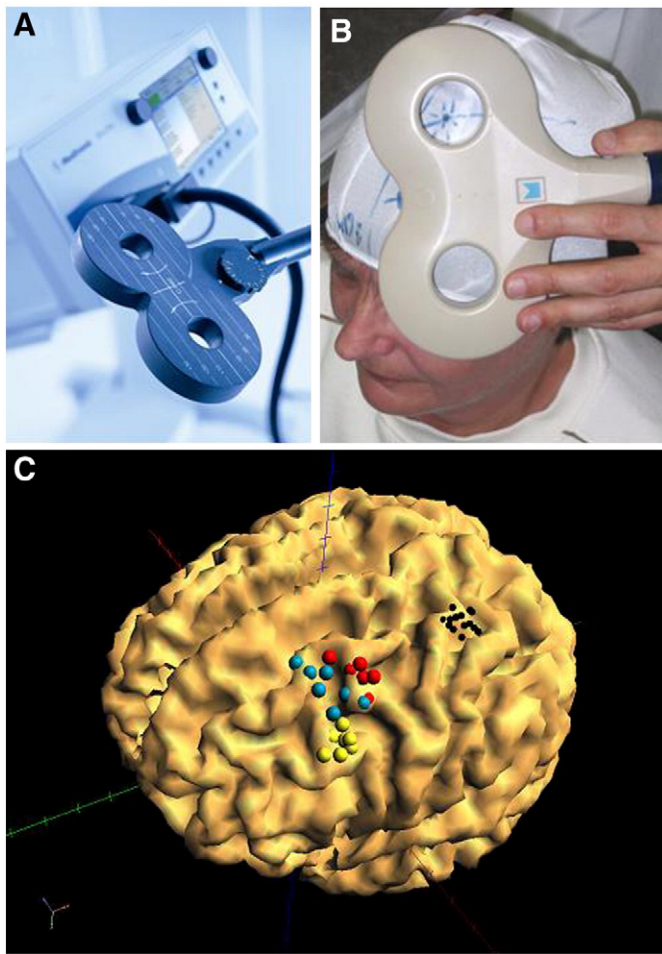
(A) rTMS of the dorsolateral prefrontal cortex. In the majority of studies rTMS has been applied in repeated sessions (1000 to 3000 stimuli/d) once daily during working days and the total duration of treatment has varied between 2 and 6 weeks. (B) The most common coil position targets the left dorsolateral prefrontal cortex by measuring 5 cm anterior (on the skull surface) to the optimal position for evoking a motor evoked potential in hand muscles. However, a considerable variability occurs with this approach, as demonstrated in a study applying neuronavigated rTMS (Herwig et al., 2001). The small black dots indicate the optimal sites for abductor pollicis brevis muscle stimulation over the motor cortex i.e. the region around the lateral edge of the hand knob. The larger dots indicate the rostral coil positions over the different Brodman areas: blue BA 6, red BA 6/8 and 8, yellow BA 8/9 and 9. Talairach coordinates before and after “standard positioning” of the coil are visualized in an individual surface rendered MRI of the brain (white matter segmentation), which was transformed into Talairach space. Reprinted from *Biological Psychiatry* Vol. 50; Herwig U, Padberg F, Unger J, Spitzer M, Schonfeldt-Lecuona C. Transcranial magnetic stimulation in therapy studies: examination of the reliability of “standard” coil positioning by neuronavigation; pp. 58–61; Copyright (2001), with permission from Elsevier Science.
